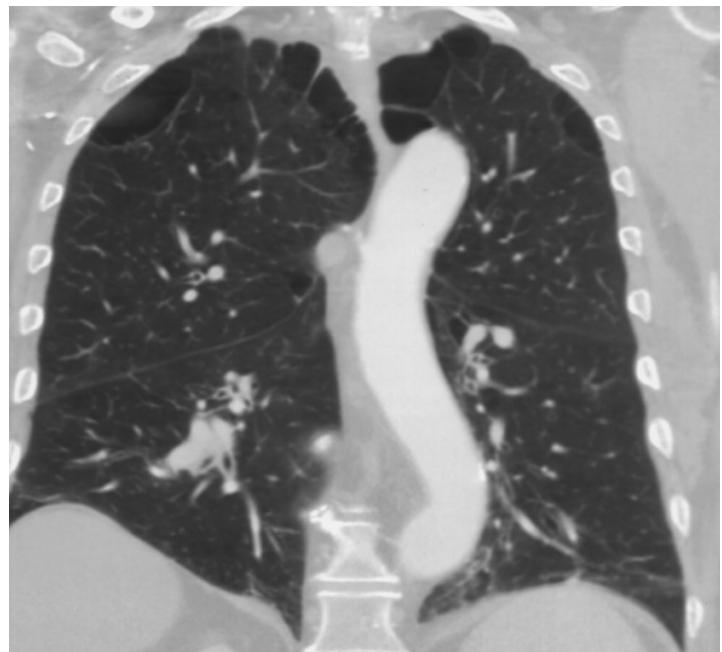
CT image of paraseptal emphysema. The coronal reconstruction clearly shows large apical emphysematous bullae that typically occur along the pleura.
